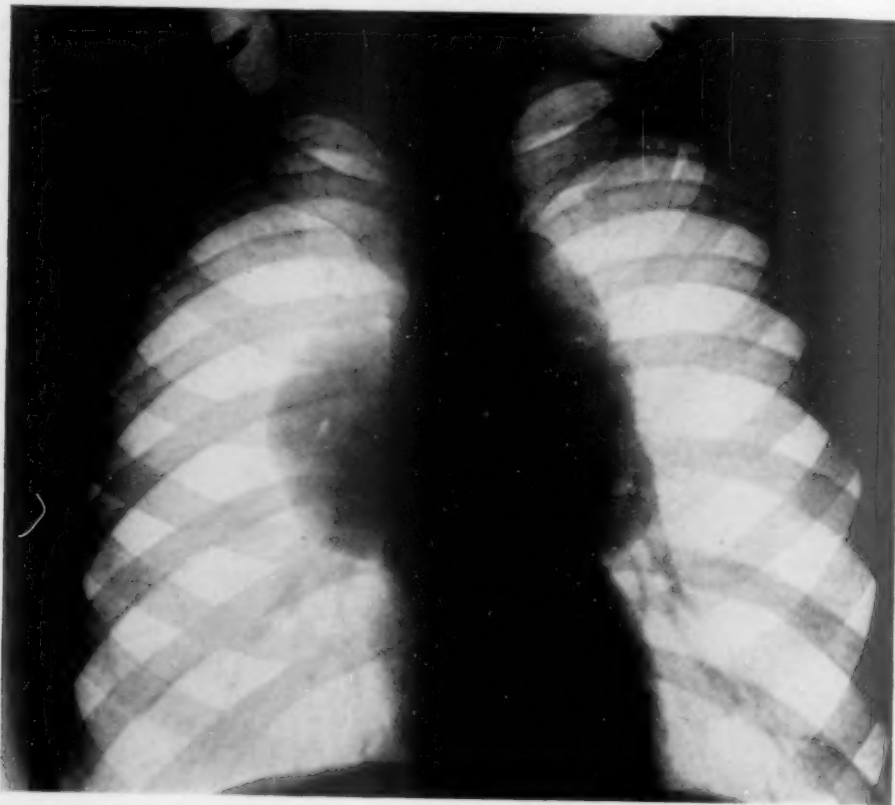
X-ray of Case VIII, showing the large centrally placed shadow in the thorax.
